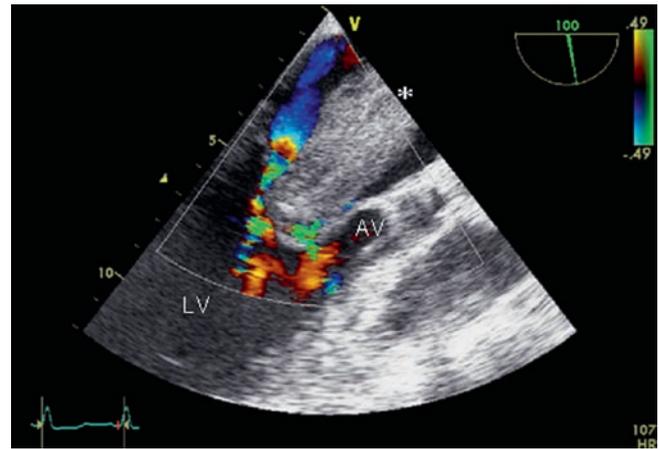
Undifferentiated primary cardiac sarcoma (*asterisk*) in a 67-year-old female patient with the history of progressive dyspnea due to functional mitral stenosis caused by diastolic occlusion of mitral inflow by the large sarcoma shown by colour Doppler. Note the similar appearance of the sarcoma in trans-oesophageal echocardiographic imaging compared to the myxoma in Fig. 29.1 except for the sarcoma's origin from the left atrial roof. LV left ventricle; AV aortic valve
